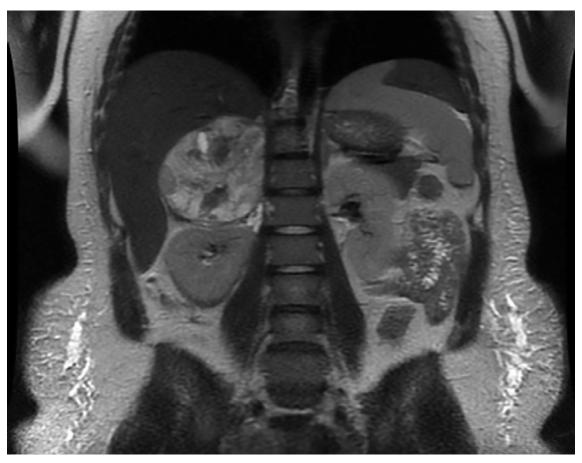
Postpartum MRI of neck, chest abdomen and pelvis, showing a large mass arising in the region of the right adrenal gland (consistent with a phaeochromocytoma). It abuts a number of adjacent structures but does not obviously appear to be invading any of these structures. No evidence of any metastatic disease identified within the abdomen. No obvious evidence of any other masses identified other than the patient's physiologically enlarged postpartum uterus.
